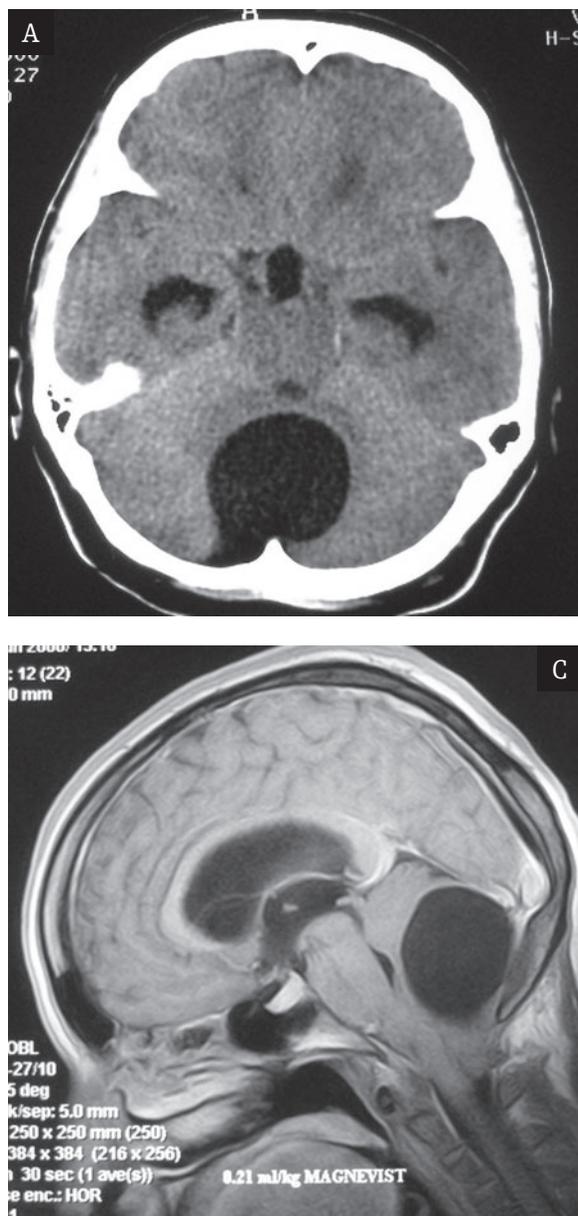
An Arachnoid Cyst (AC). Axial CT (A) scan and MR axial FLAIR (B), and sagittal T1-weighted (C) images show large round fluid collection located posteriorly to the vermis and cerebellar hemispheres. The cyst produces marked mass effect with compression of the vermis and the fourth ventricle, with no communication with the fourth ventricle; these signs are typical of AC.
